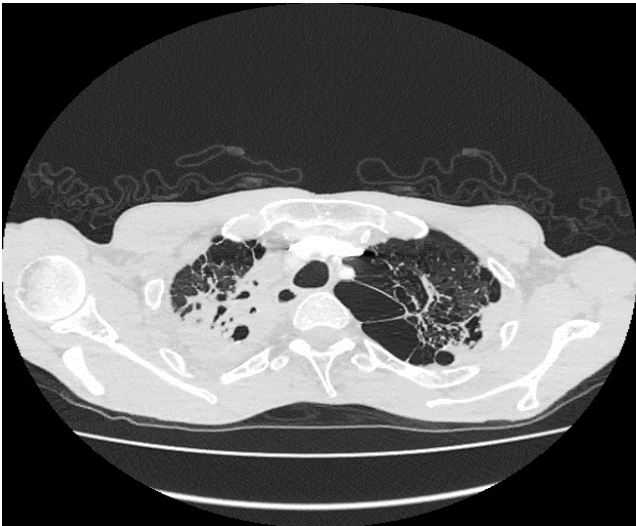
Patient 2 (chest CT scan).
